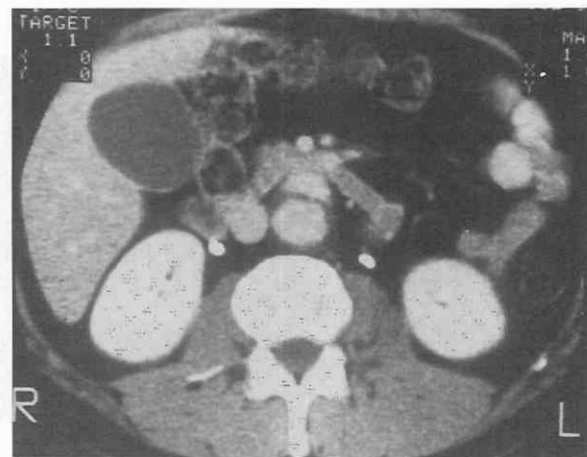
Aortic dissection. CT enhanced scan shows an aortic dissection in the midabdomen. The scan easily demonstrates the intimal flap between the anterior true lumen and the posterior false lumen.
